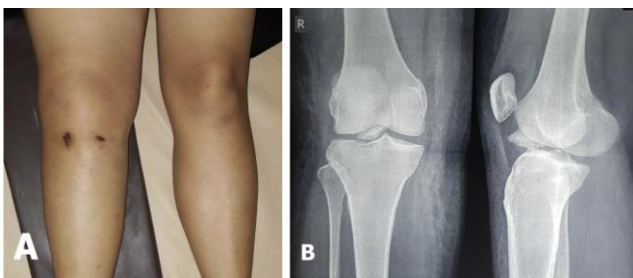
Clinical picture of the knee at 1 day after trauma. The right knee was swollen with skin brushing and excoriation on anterior part A); Preoperative plain radiograph of the knee. The displaced fragment located at anterior compartment of the knee, masquerading of an ACL fragment B)
